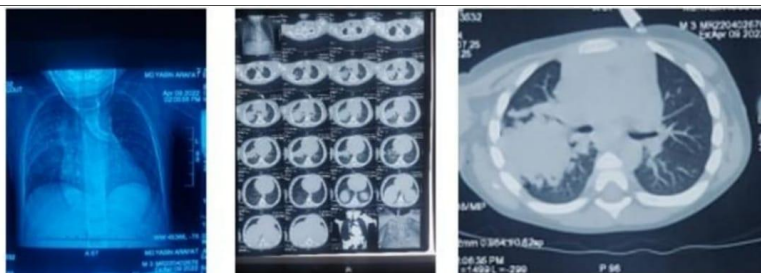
Chest roentgenogram showing diffuse opacity involving the mid zone of the right lung, Figure 1B: CT scan showing AVM occupying the right lung. Fig. 1C. CT Scan slice showing the AVM extending in very close to the right principal bronchus, Figure 1C: CT Scan slice showing the AVM extending in very close to the right principal bronchus.
